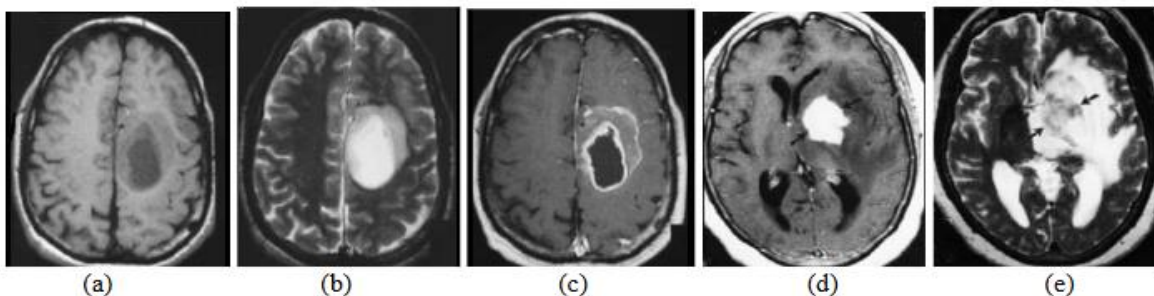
A set of brain tumor images from MRI of brain output cited by Herbert H. Engelhard et al. (2003)
